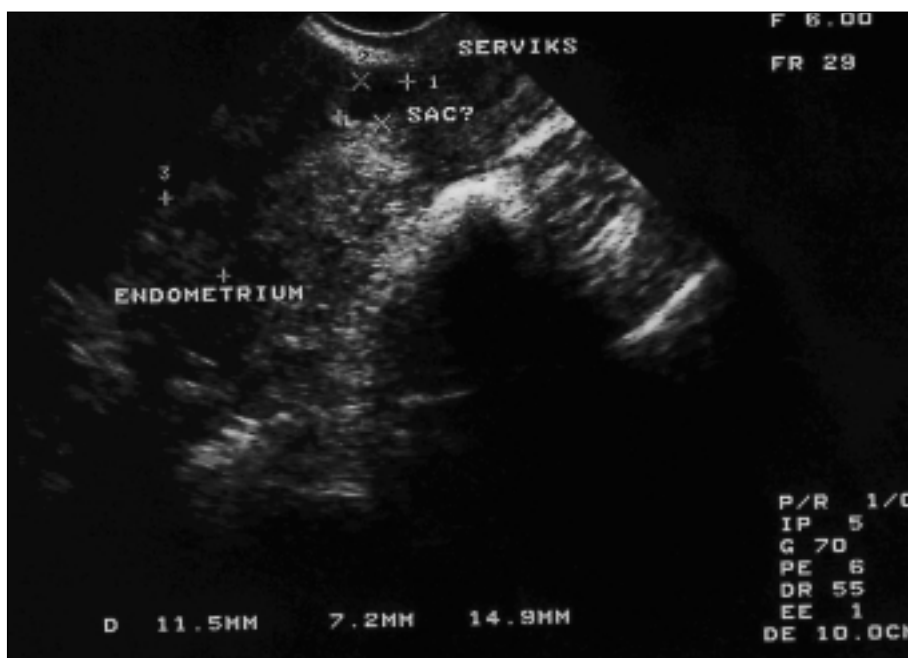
Ultrasonographic image of scar pregnancy.
